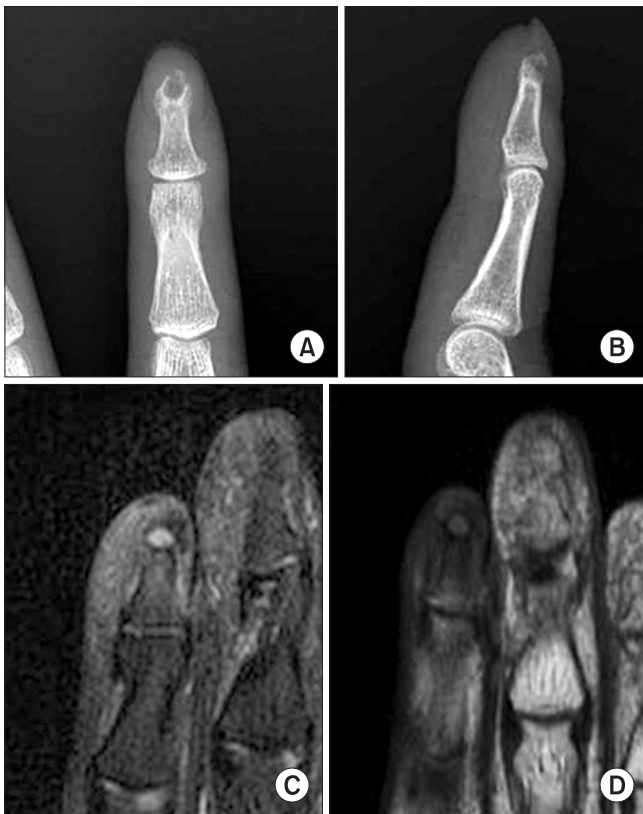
(A, B) Radiographs show a round shaped radiolucent lesion with cortical expansion and thinning of left 4th finger. (C, D) T1-weighted and T2-weighted MR images show lower and higher signal lesion at the left 4th distal phalanx.
